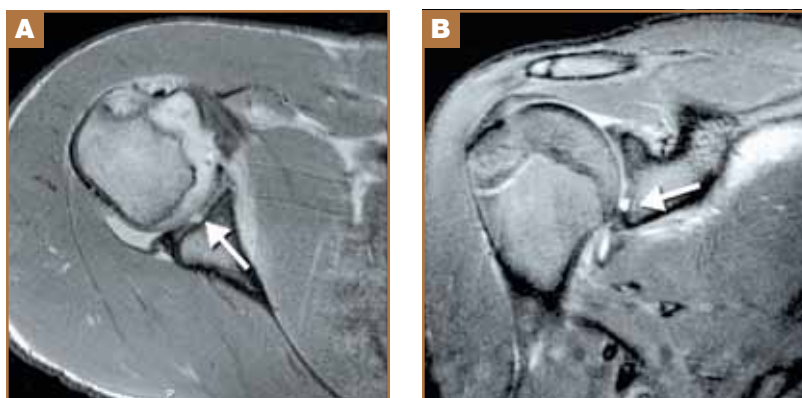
Right shoulder. (A) Axial MRI image of the right shoulder demonstrating anterior glenoid chondral injury (arrow) and labral tear. (B) Coronal MRI image of the right shoulder demonstrating inferior glenoid chondral injury (arrow).
